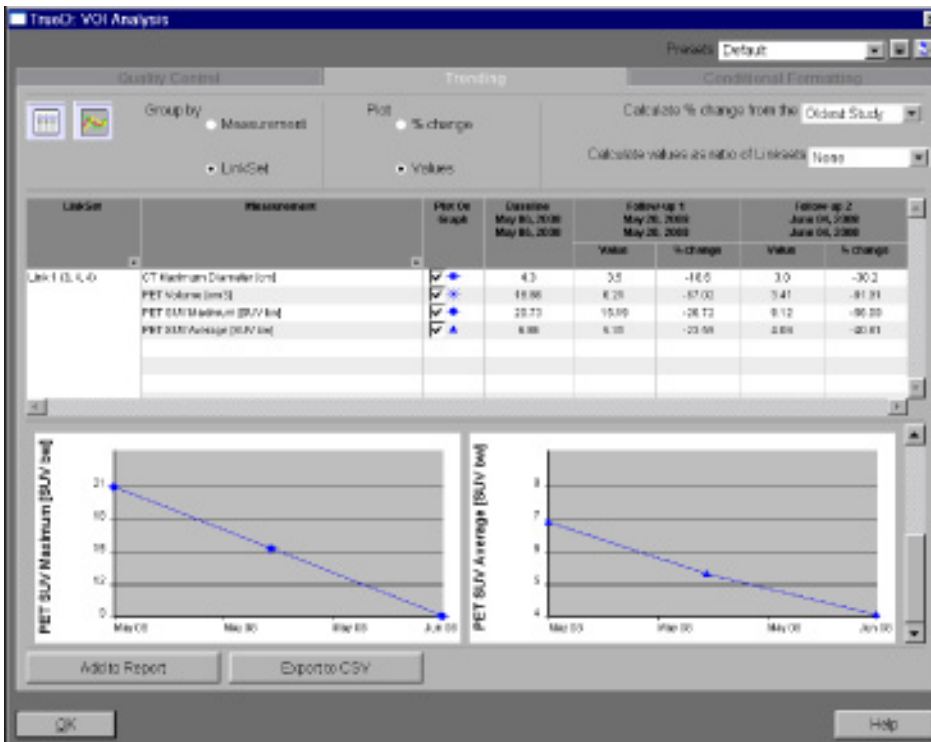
Three-time point tumor trending with TrueD enables analysis of changes in SUV across time points. Data courtesy of University of Tennessee Medical Center, Knoxville, TN.
